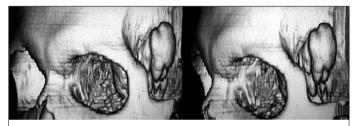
3D reconstruction of multiplanar CT showing lesion projecting towards the ipsilateral temporal fossa.
